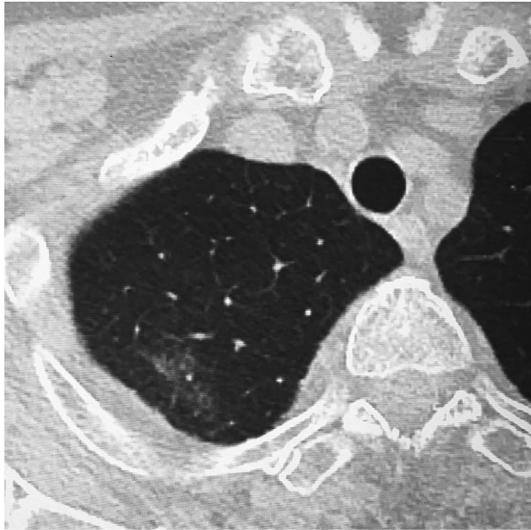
Computed tomography scan of the right lung. A very small area of ground-glass opacity is observed in the apex of the right lung after 16 days of osimertinib treatment.
